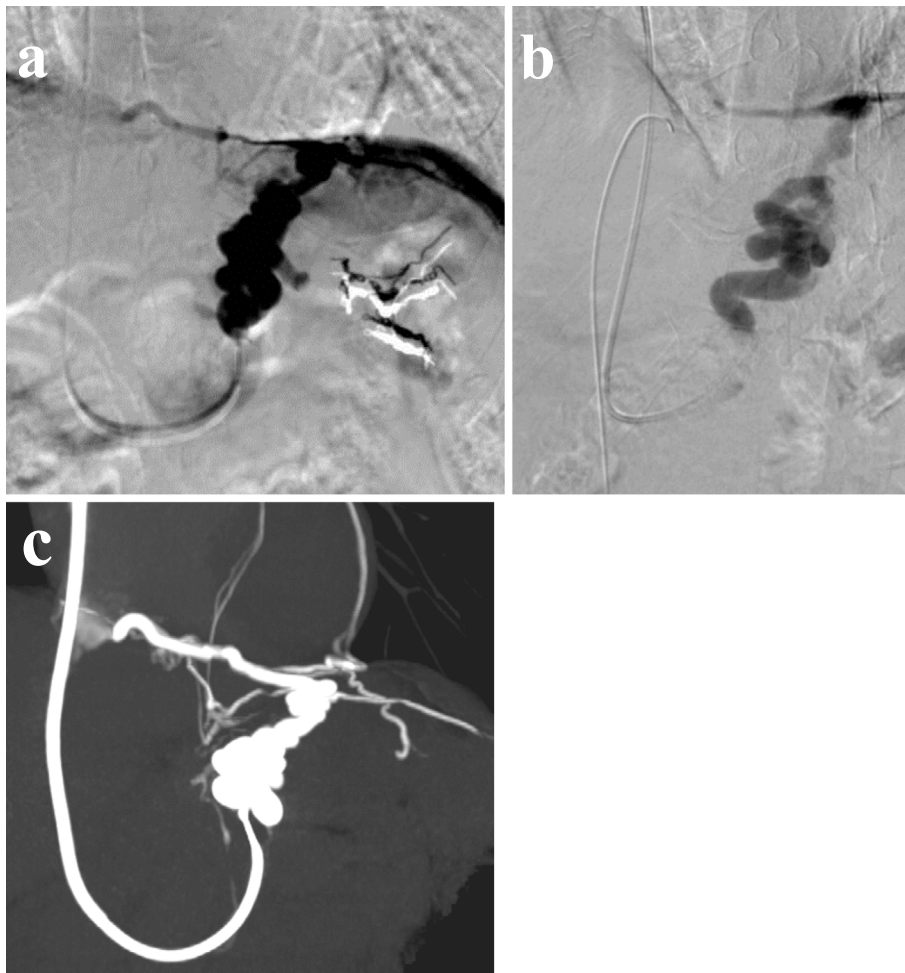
We punctured the right internal jugular vein and introduced an 8-Fr balloon catheter with a 20-mm diameter. We advanced it to the left renal vein and occluded the end of the efferent vein (a). We then tried to cannulate the inferior phrenic vein from the inferior vena cava (IVC). We injected contrast medium via the balloon catheter and performed CT to determine where the end of the inferior phrenic vein was located (b, c). Although we used various types of catheter, such as Cobra, Multipurpose, and Michaelson types, we were unable to cannulate due to indentation.
